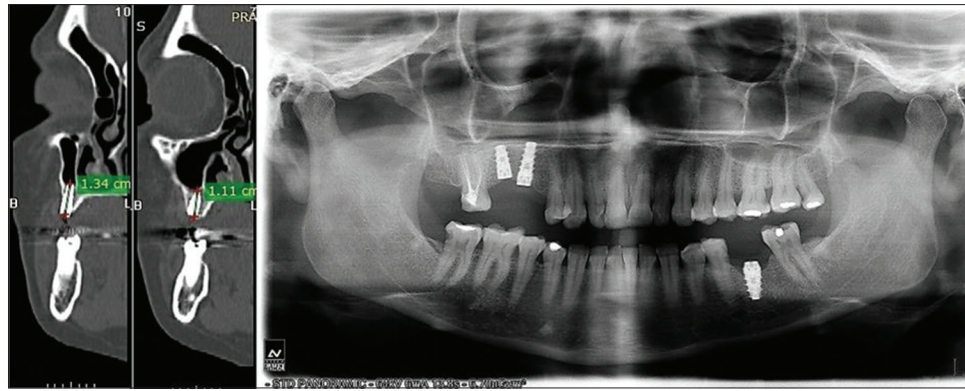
Six-month follow-up OPG and CT scans
